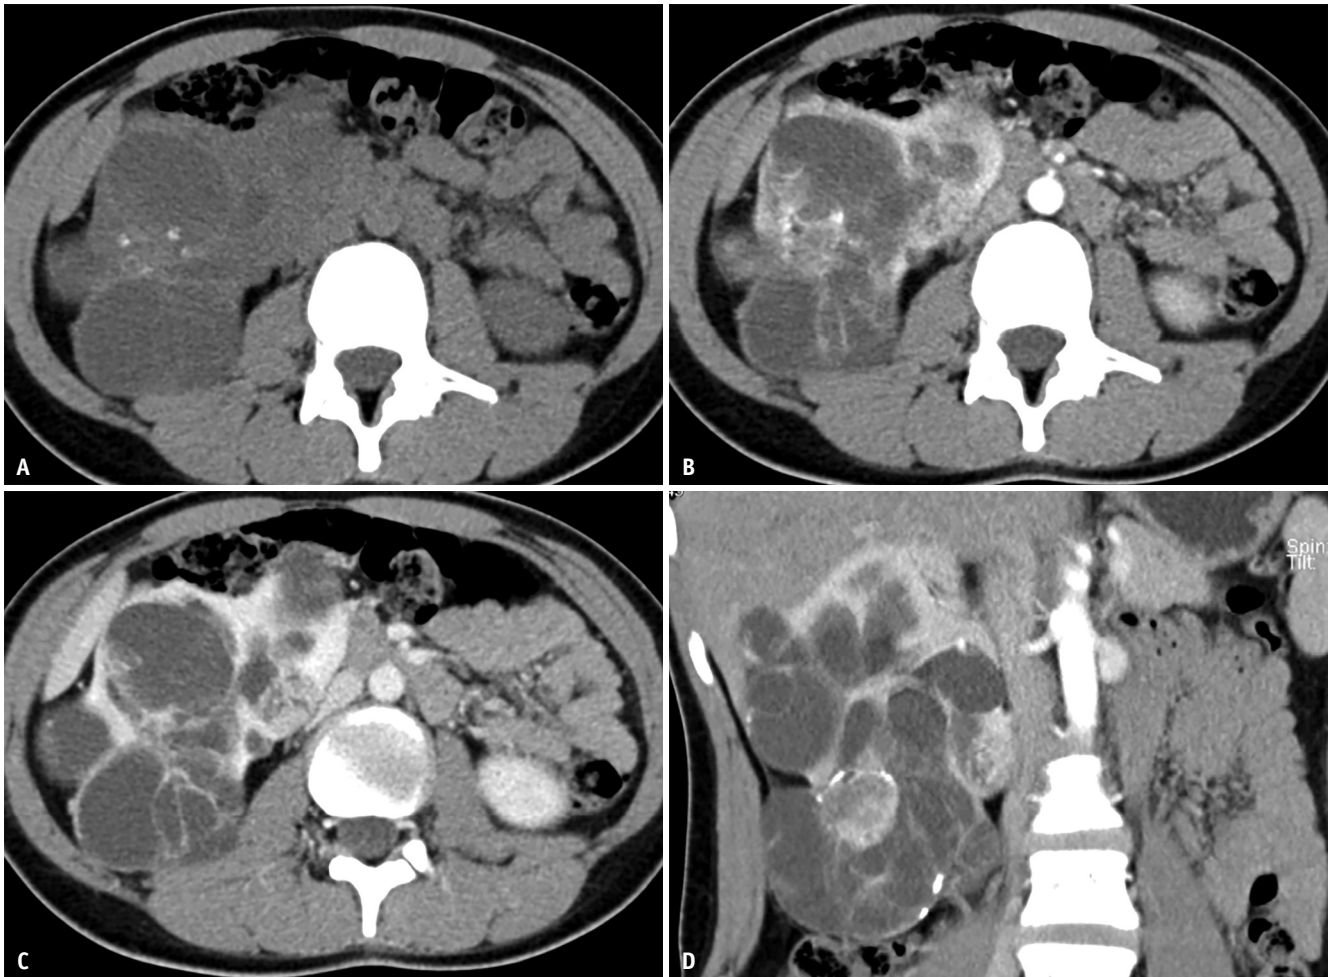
A 13-year-old girl with predominantly cystic fumarate hydratase-deficient renal cell carcinoma with germline mutation in the right kidney. A-D. An unenhanced CT image (A) shows multiple cysts and calcifications. Corticomedullary (B) and nephrographic (C, D) phase CT images show the eccentric location of the solid portion.
